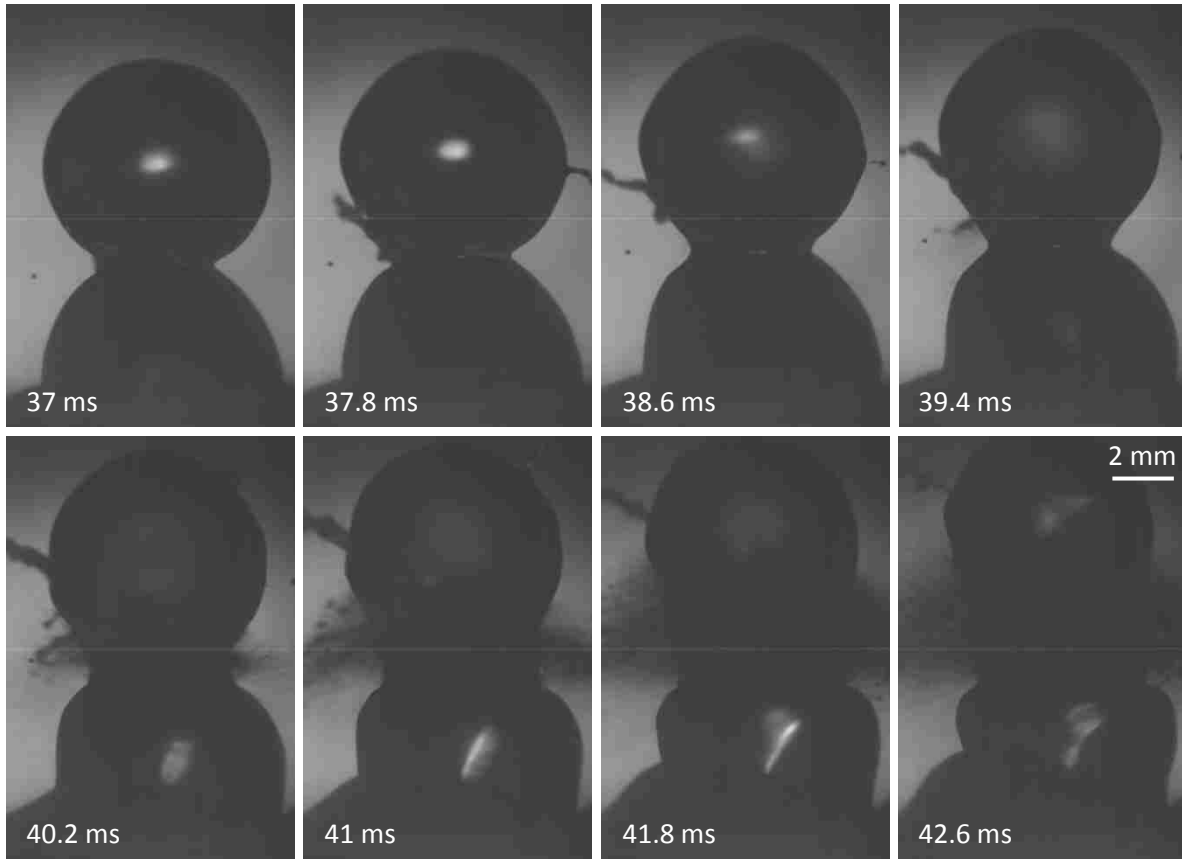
Selected frames from the high speed video of an air-water interface exposed to 155 kHz ultrasound at 264 W/cm^2 ($p_{\text{a}}/p_{\text{a}} = 2.8 \text{ MPa}$) and filmed at 5000 fps. The first frame shows the drop chain with no jetting. In the second frame, a jet emerges from the right hand side of the top droplet, with some jetting from the neck region between the two droplets. While the jet on the right is released in the third frame, the instability on the left continues and moves upward. By the fourth frame, an additional jet has formed on the left side of the drop chain. The new jet is more developed by the fifth frame and excites a jet on the opposite side of the drop chain; the fifth frame also shows one additional jet being emitted from the upper right hand side of the top droplet. The sixth through eighth frames show that the jetting from between the top two droplets continues, releasing many fine droplets from the chain. The total ultrasound exposure time was 64.5 ms (10,000 cycles).
